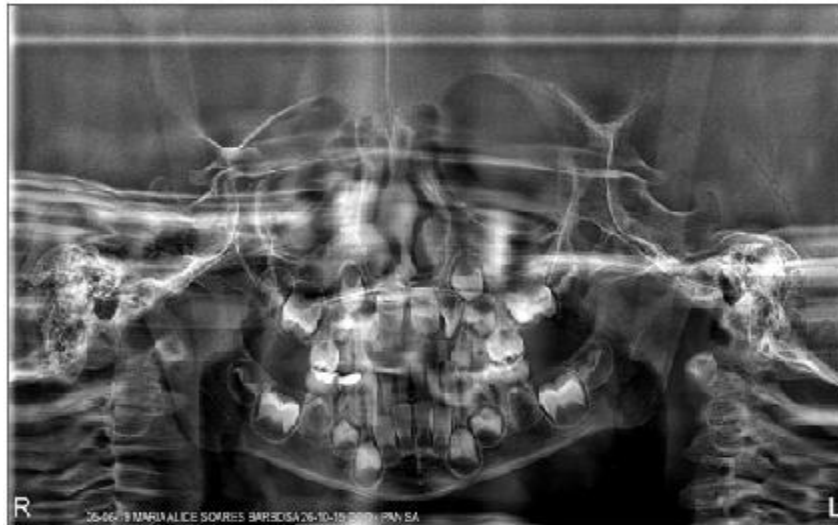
Panoramic radiograph showing the absent of the enamel lamina, while the dentin and the pulp show normal aspects
